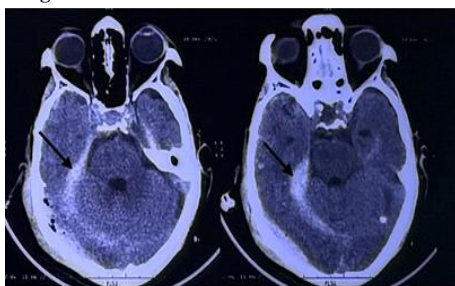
Follow-up CT brain which shows intraventricular haemorrhage (black arrow)
